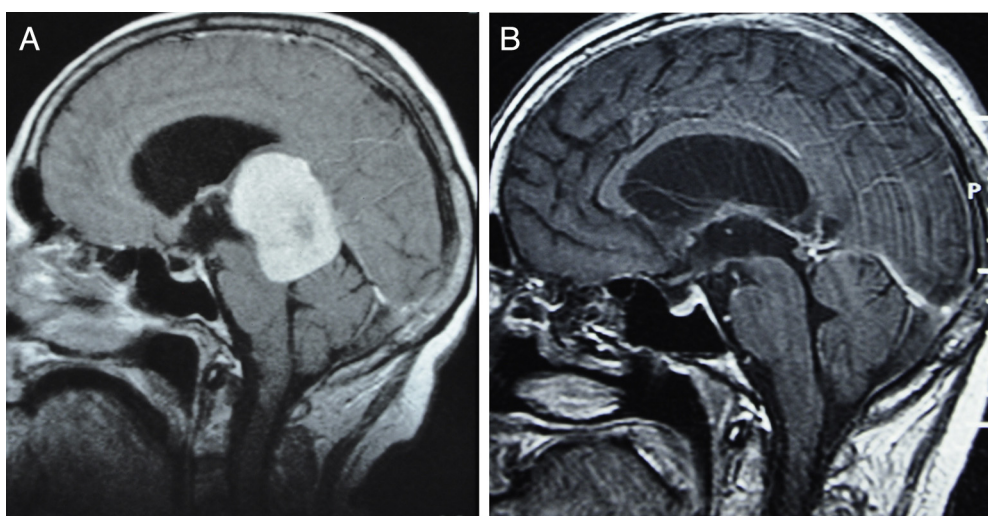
(A) Preoperative sagittal T1 contrast enhanced MR image demonstrating falcotentorial meningioma. (B) Postoperative sagittal T1 contrast enhanced MR image obtained after complete resection of the tumor.
